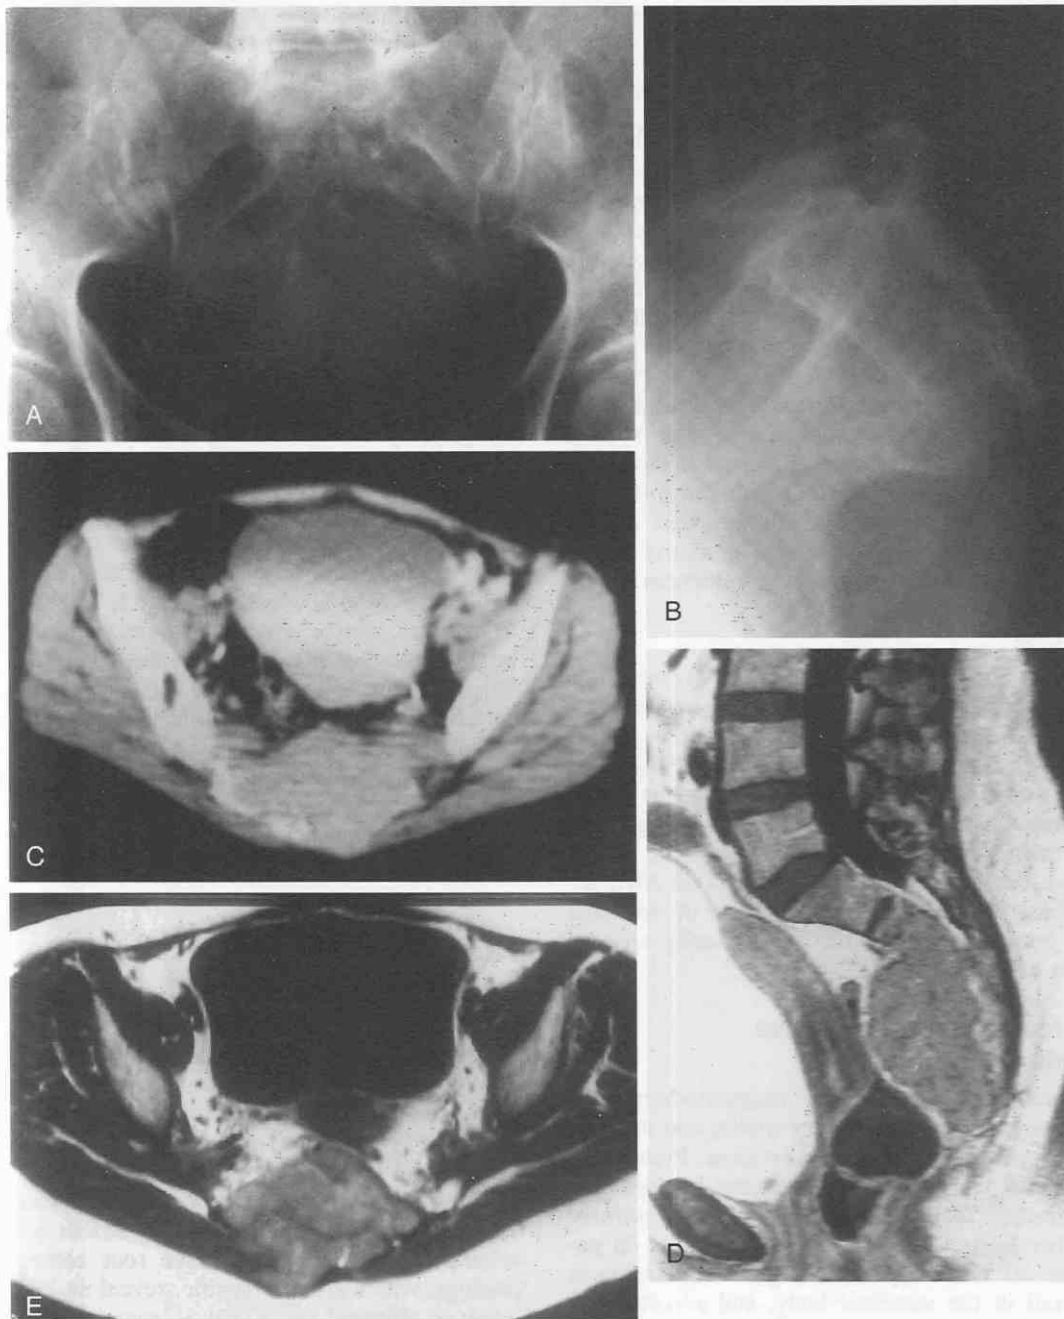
A, Plain film AP view of the sacrum. There is destruction of the inferior and left aspect of the sacrum. B, Lateral plain film of the sacrum demonstrating destruction of the inferior sacrum. C, Axial CT image of the sacrum. The soft tissue mass that is destroying the sacrum has proved to be a chordoma. This mass is in the usual sacrococcygeal region of the spine. D, T1-weighted sagittal image (with contrast enhancement) of the sacrum nicely demonstrating the extent of the soft tissue tumor, which exhibits mild enhancement. The mass is causing anterior displacement of the rectum. E, T1-weighted axial image of the sacrum demonstrating the chordoma and its effects on the surrounding tissues.
